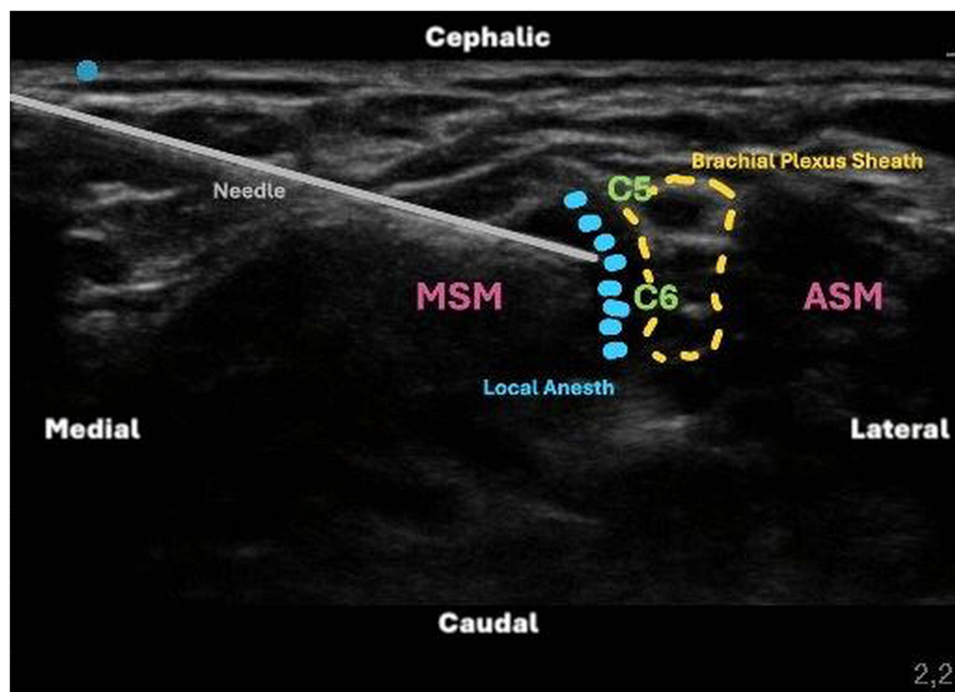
Ultrasound-guided ExF approach for ISBPB. The needle tip is positioned lateral to the brachial plexus sheath, without penetrating the paravertebral fascia. Yellow dashed lines delineate the brachial plexus sheath between the C5 and C6 nerve roots. Blue dots mark the site of local anesthetic injection administered outside this sheath. Abbreviations: MSM, Middle Scalene Muscle; ASM, Anterior Scalene Muscle; Local Anesth, Local Anesthetic.
